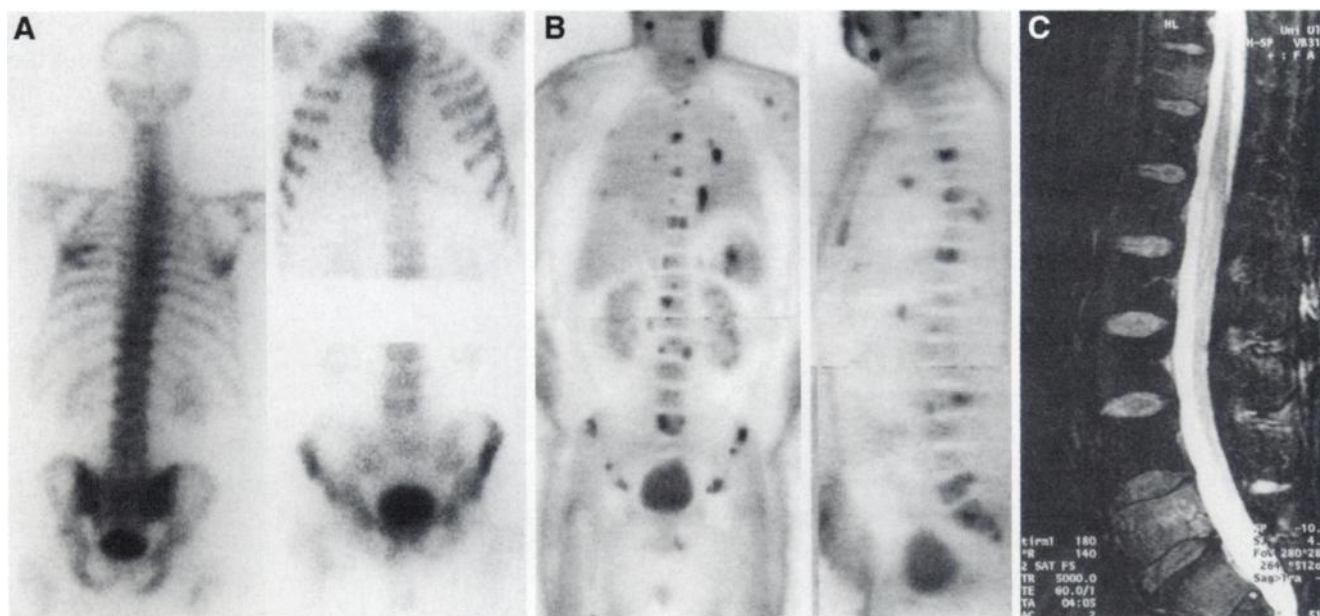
Highly malignant NHL. (A) There is no suspicious tracer uptake at bone scintigraphy, but (B) FDG PET shows enhanced FDG uptake in multiple axial and peripheral skeletal regions typical of malignant disease. (C) Lymphomatous infiltration was confirmed by MRI using short inversion-time inversion recovery sequence.
